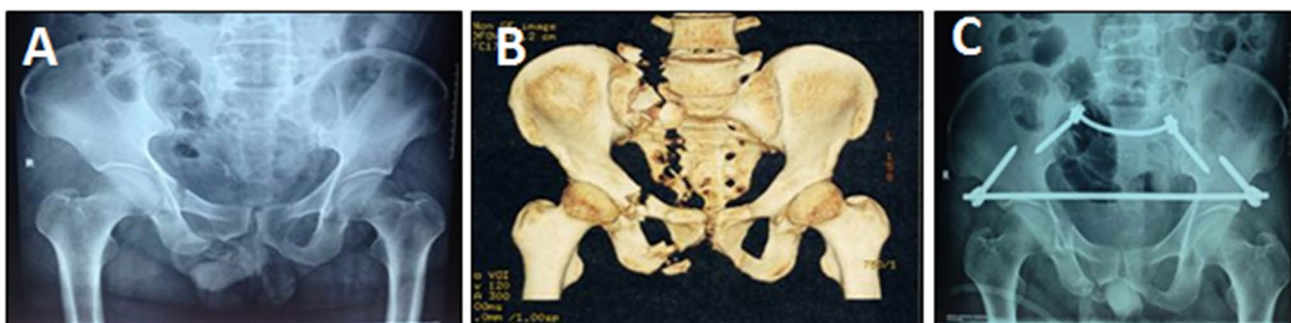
A 48-year-old male patient with traffic accident. a A vertically and rotationally unstable pelvic fracture with sacroiliac joint dislocation (Tile C type). b 3D computed tomography scans and c after stabilization with an anterior INFIX in combination with a transiliac internal fixator (TIFI)
